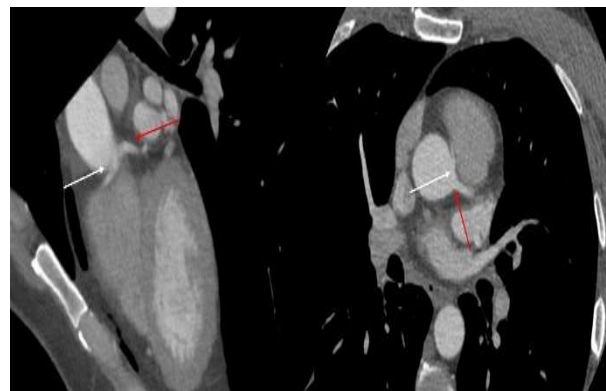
Coronary CTA. Curved multiplanar reformatted coronary CTA images showing the anomalous origin of the right coronary artery (white arrow). The left main artery originates from left sinus of Valsalva (red arrow). CTA, coronary computed tomography angiography.
